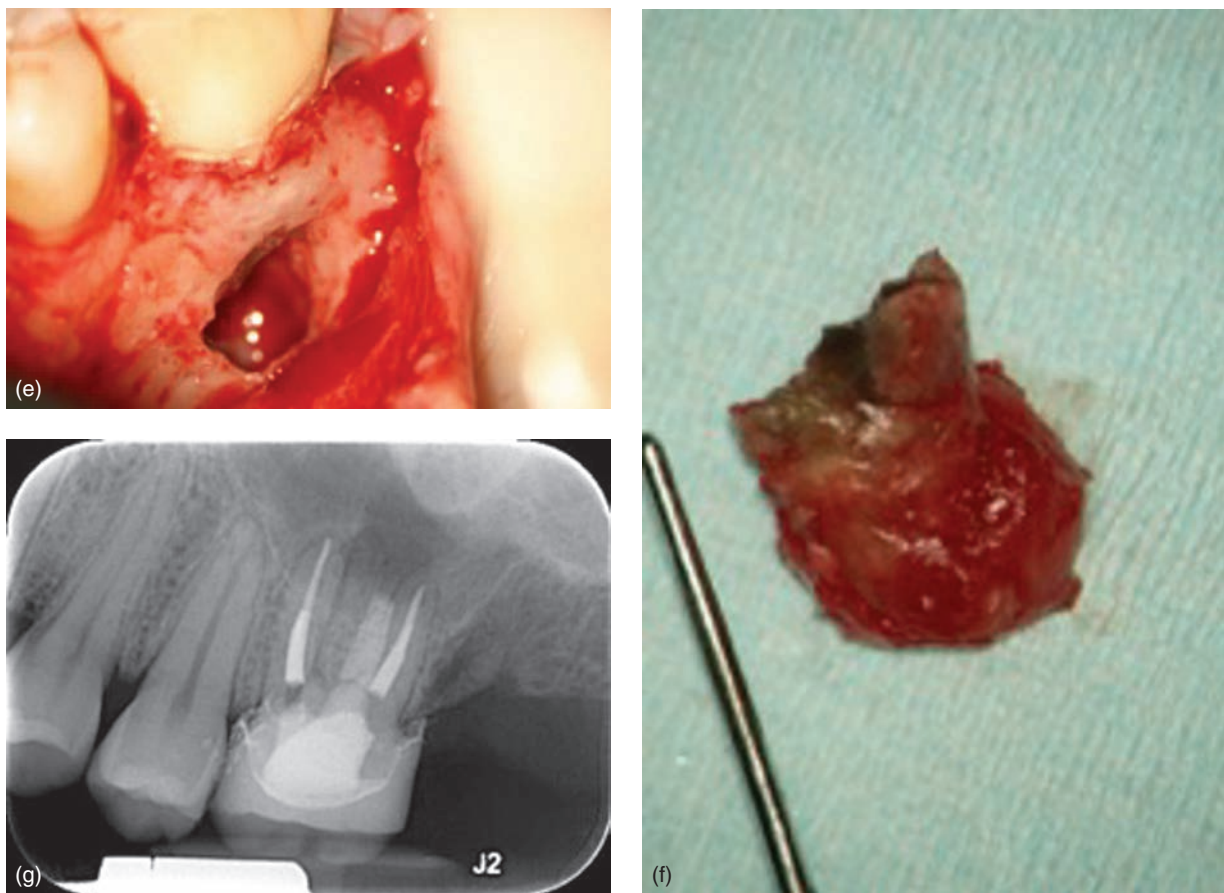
(Continued) (e) Osteotomy completed. (f) Root tip with granuloma. (g) Postop radiograph. (Courtesy of Dr David Moore.)
